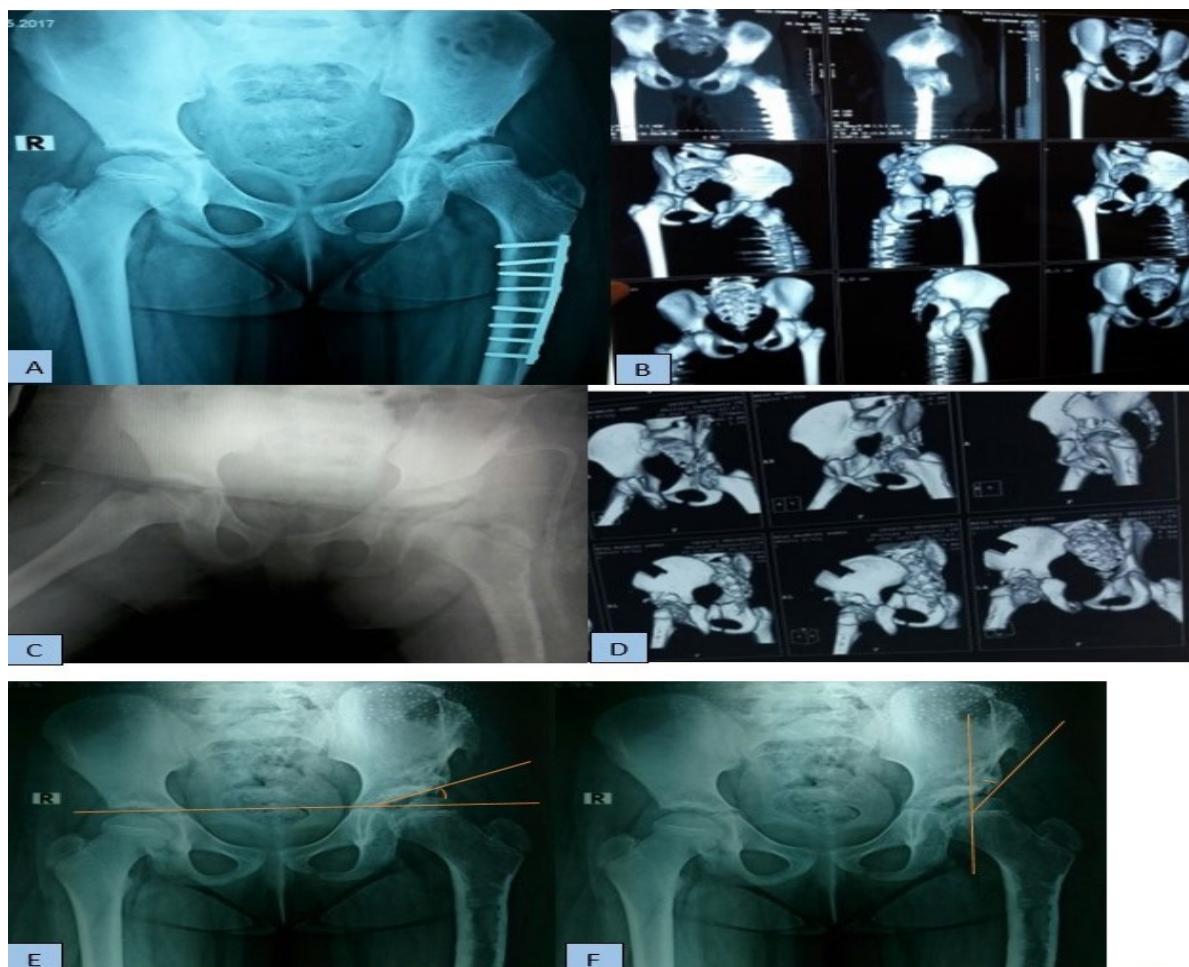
(A): Plain radiography pelvis anteroposterior view of seven years old female showing Lt residual acetabular dysplasia (AI= 350). Open reduction and femoral derotation osteotomy was performed at the age of three years; (B): 3DCT of the same patient shows anterolateral acetabular deficiency; (C): Postoperative plain radiography pelvis anteroposterior view after Dega acetabuloplasty; (D): 3DCT shows the osteotomy site, the position of graft and the correction of the residual acetabular dysplasia; (E), and (F): follow-up radiography shows good remodeling of the acetabulum (AI= 23, CE angle= 32.6) and the correction of acetabular dysplasia.
